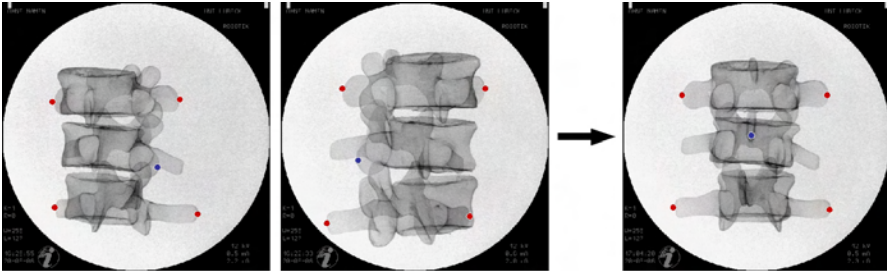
Defining landmarks on two radiographs for exact automatic a.-p. positioning on a vertebra.
